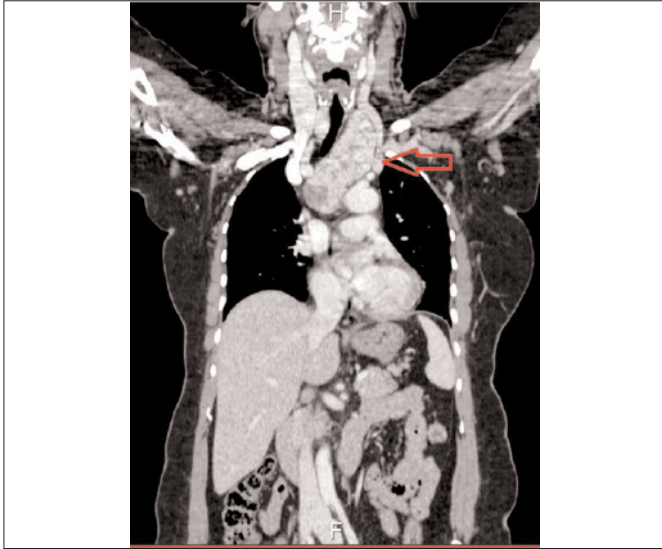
CT scan (chest) showing mediastinal mass and the deviation of trachea towards right side.
